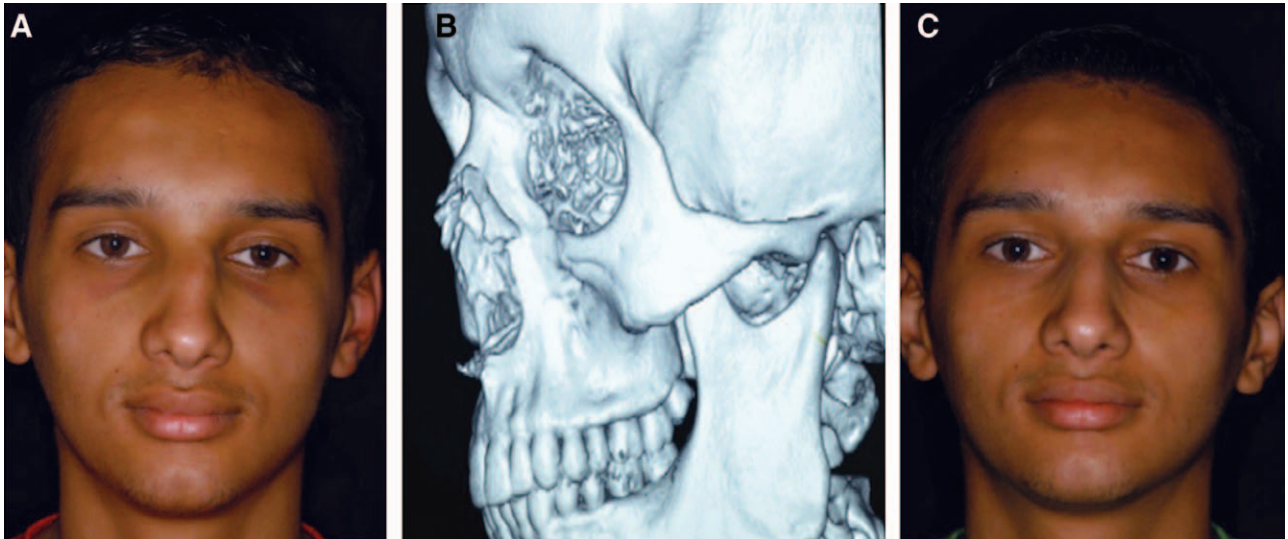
A, Nasal fracture sustained from head-to-head contact during a soccer game. B, CT demonstrating comminuted fracture of the nasal bones. C, One-year follow-up after closed reduction of the nasal fracture. CT indicates computed tomography.
